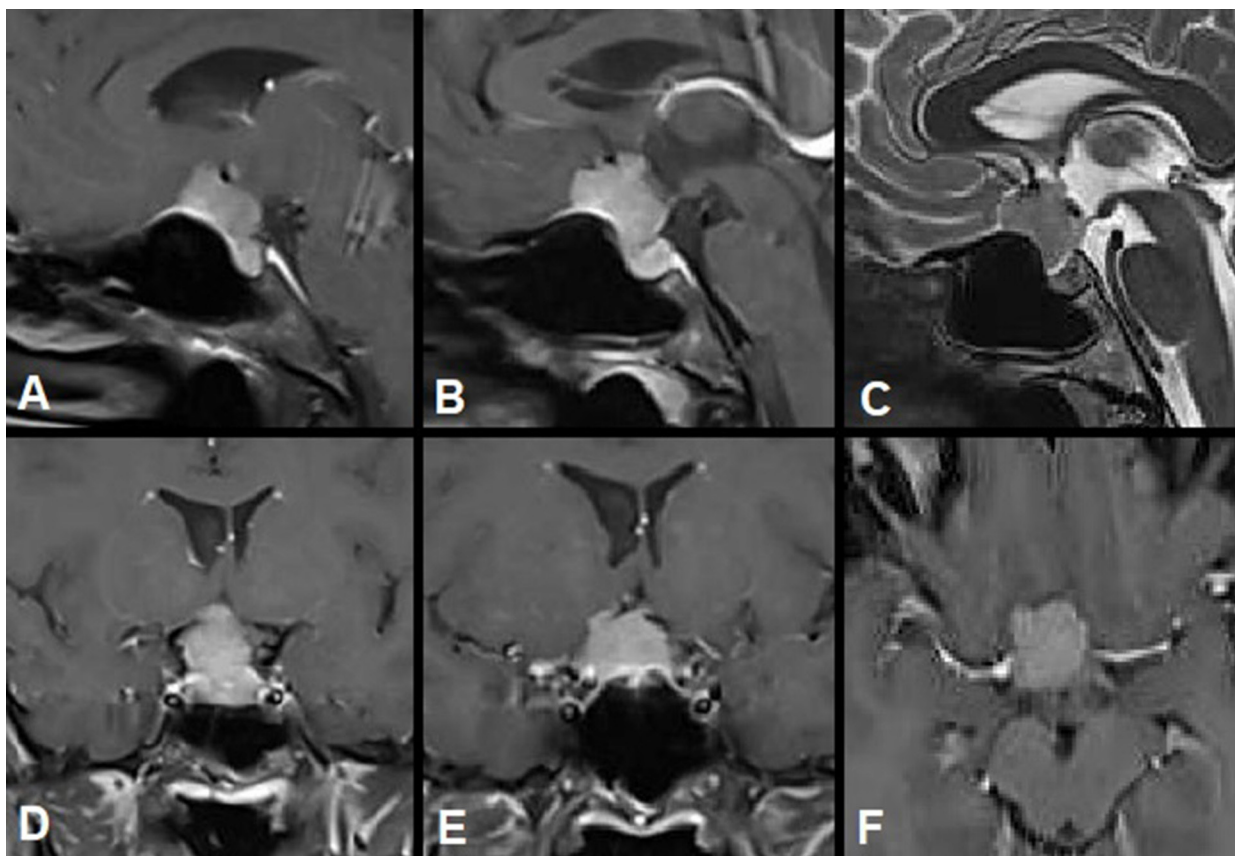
Intravenous-enhanced MRI of the sellar region. Meningioma of the tuberculum sellae with contraindications for endoscopic endonasal intervention: A, B, C - coverage of the anterior cerebral artery - anterior communicating artery complex and spread towards the posterior communicating artery; D, E - asymmetric spread of the tumour over the supraclinoid segment of the internal carotid artery and spread towards the posterior communicating artery; F - lateralization of the meningioma to the right, towards the posterior communicating artery
